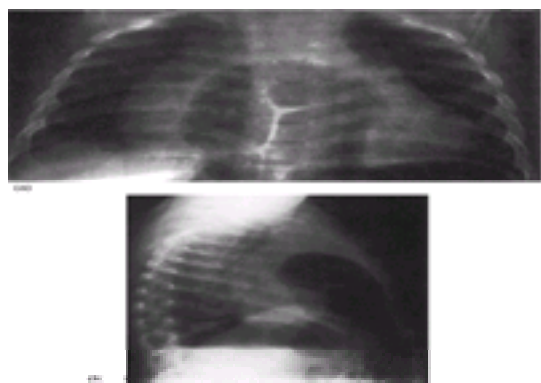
(a) Posterior–anterior chest radiograph obtained in a 4-month-old infant because of a cold. To the surprise of the pediatrician an air-filled structure was identified anterior to the heart. (b) The lateral chest radiograph confirmed the presence of an air-filled structure within the mediastinum. This child was explored through a transverse upper abdominal incision. A diaphragmatic hernia of Morgagni was found with a sac containing transverse colon. The sac was excised and the hernia readily closed. The pericardium was separate from the hernia sac.
